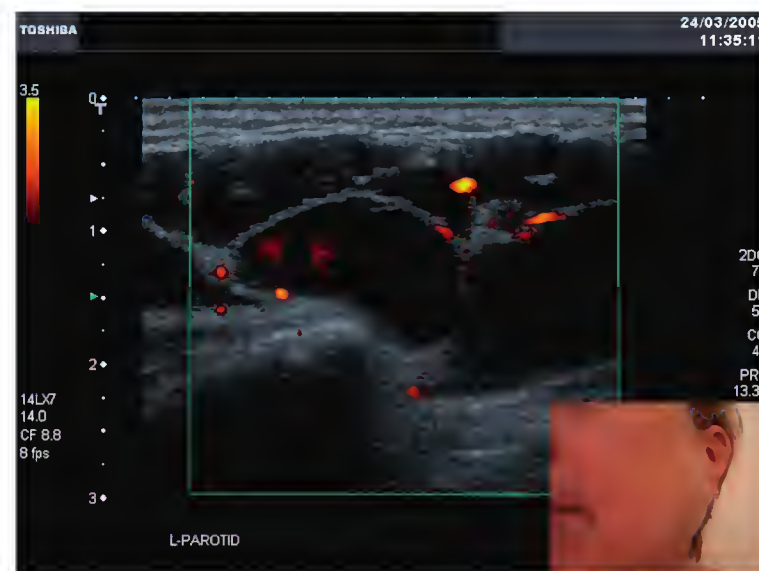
Sjögren syndrome. Ultrasound image of swollen parotid gland shows hypoechoic change in the gland with almost complete loss of normal gland tissue and increased power Doppler signal in a patient with longstanding Sjögren syndrome.
